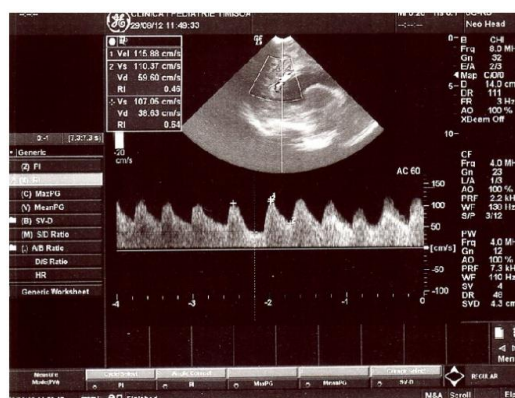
Transfontanelar Doppler: Anterior cerebral arterial resistivity index (RI)
